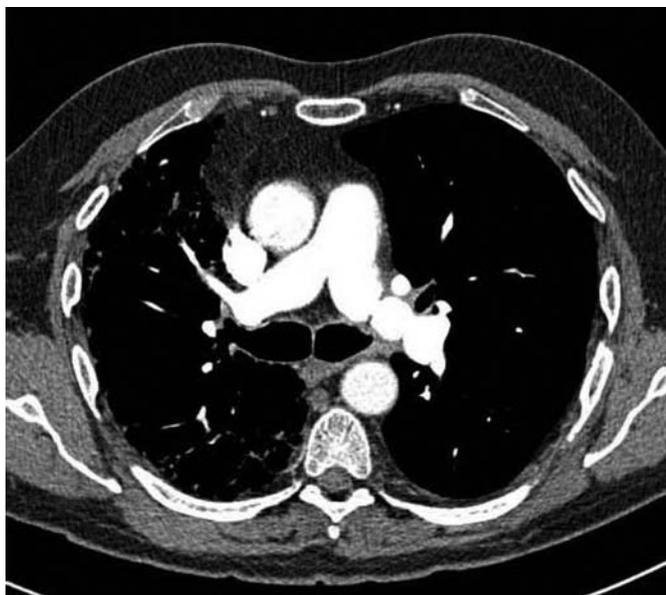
Computed tomography pulmonary angiogram showing pulmonary artery stricture.
